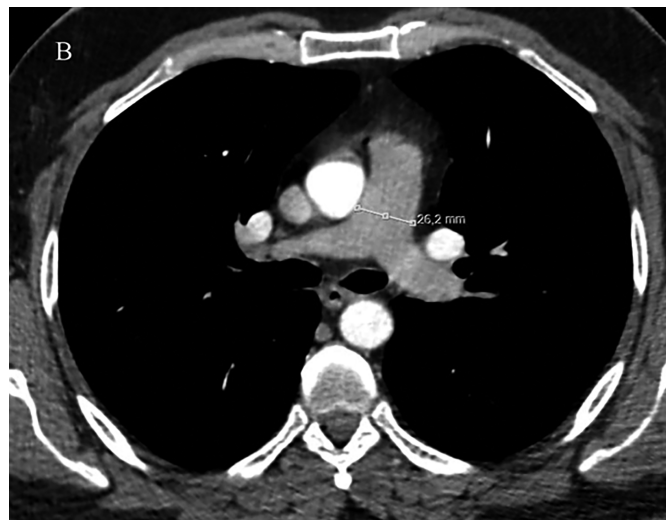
The mPA diameter was calculated in axial plane CT at the bifurcation level.
